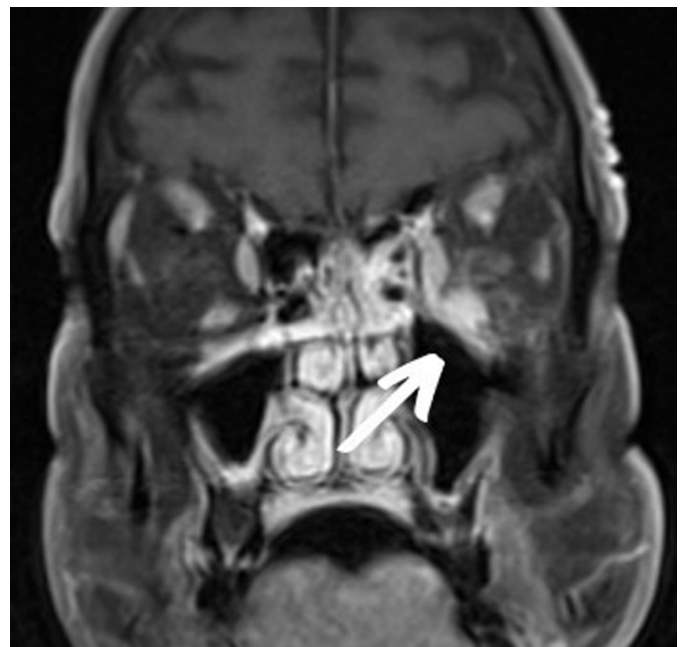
Contrast-enhanced T1-weighted magnetic resonance imaging showing expansion through erosion of the medial orbital wall and through the inferior orbital fissure.
